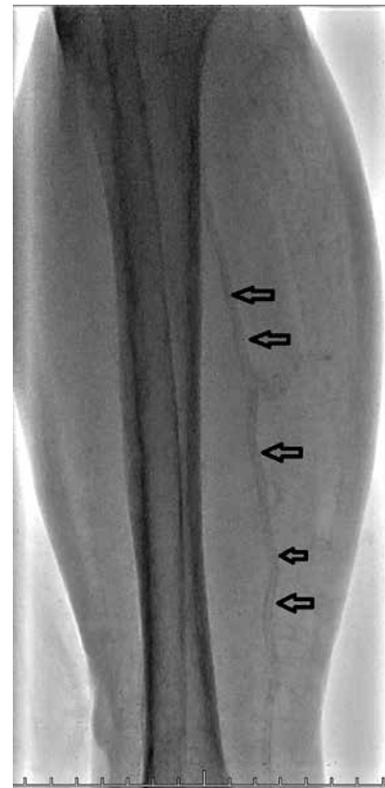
X-ray image showing calcification in the posterior tibial artery
